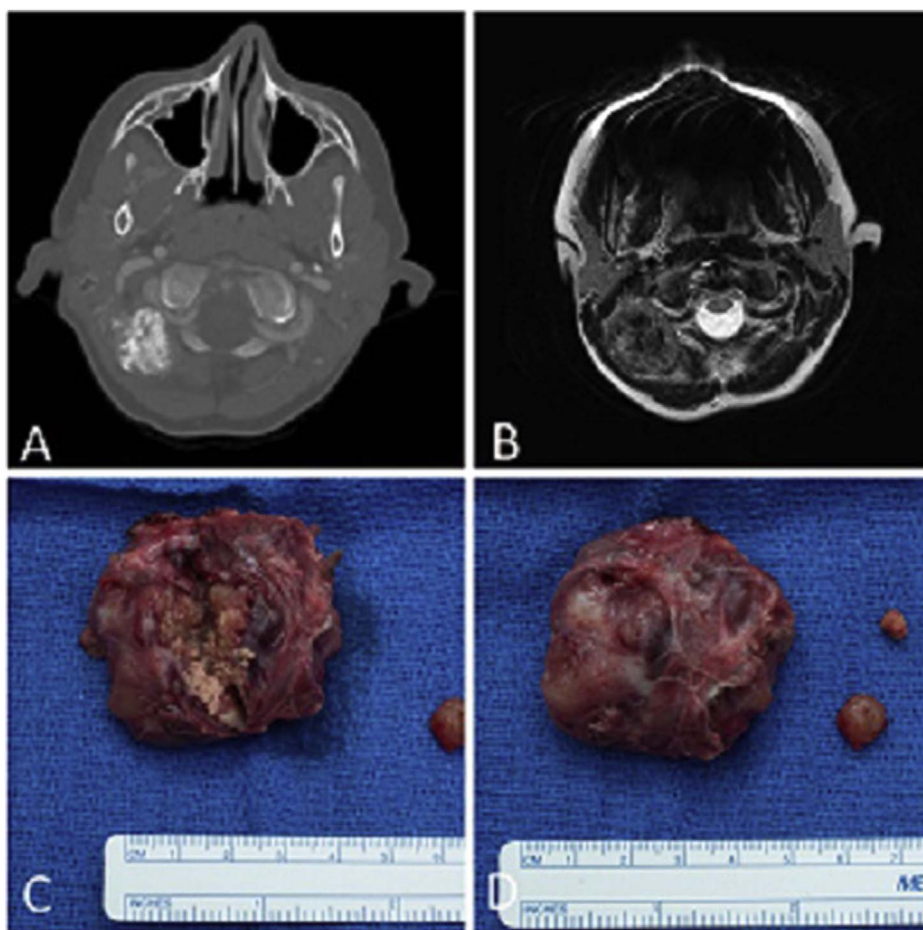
Axial imaging demonstrating calcified mass abutting the left vertebral artery with (A) CT and (B) T2 MR; appearance of the mass after excision showing (C) obvious granular calcifications and (D) external lobulation.
